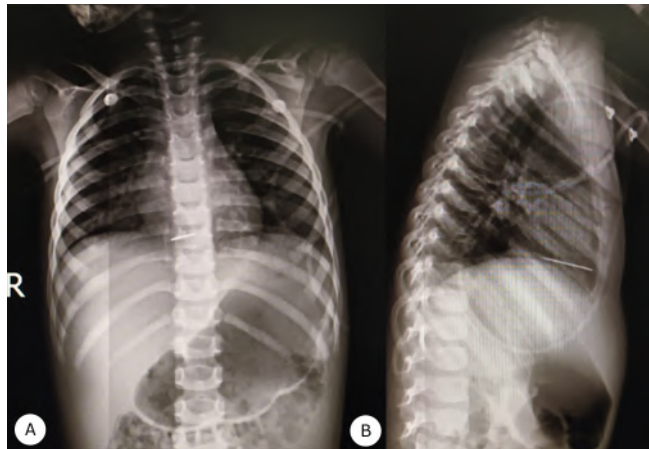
Posteroanterior (A) and Lateral (B) chest radiography views show a sewing needle in the lung cavity and the mid-mediastinum.
